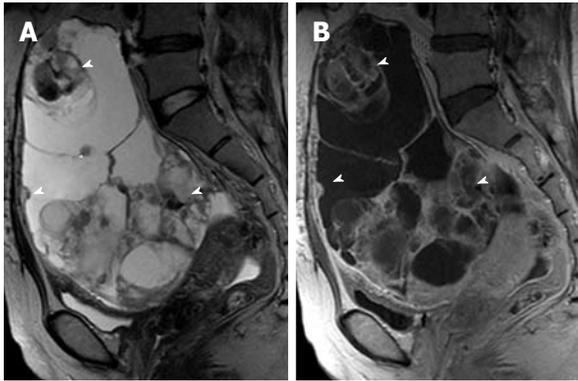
Mucinous cystadenocarcinoma of the left ovary in a 47-year-old woman. A: Sagittal T2-weighted MR image shows a huge multilocular ovarian cystic mass with multiple hypointense solid components (arrowheads); B: Sagittal contrast-enhanced T1-weighted MR image shows an ovarian cystic mass with enhancement of internal septa and solid components (arrowheads). MR: Magnetic resonance.
